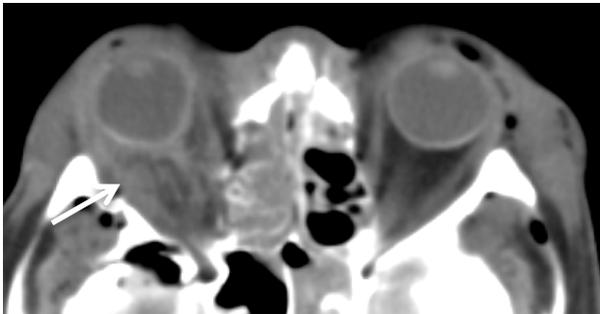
Altered morphology of right optic nerve with hemorrhage within the conus (75-year-old male). CT, transverse section: The vitreous body represents unshaped with a hemorrhage behind the globe (white arrow). The complete orbital portions are fractured. Extraocular muscles could not be identified individually.
